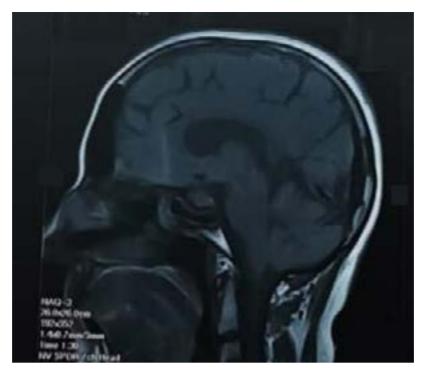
Brain MRI in a sagittal section, showing pituitary parenchyma preserved and postsurgical scar changes.
